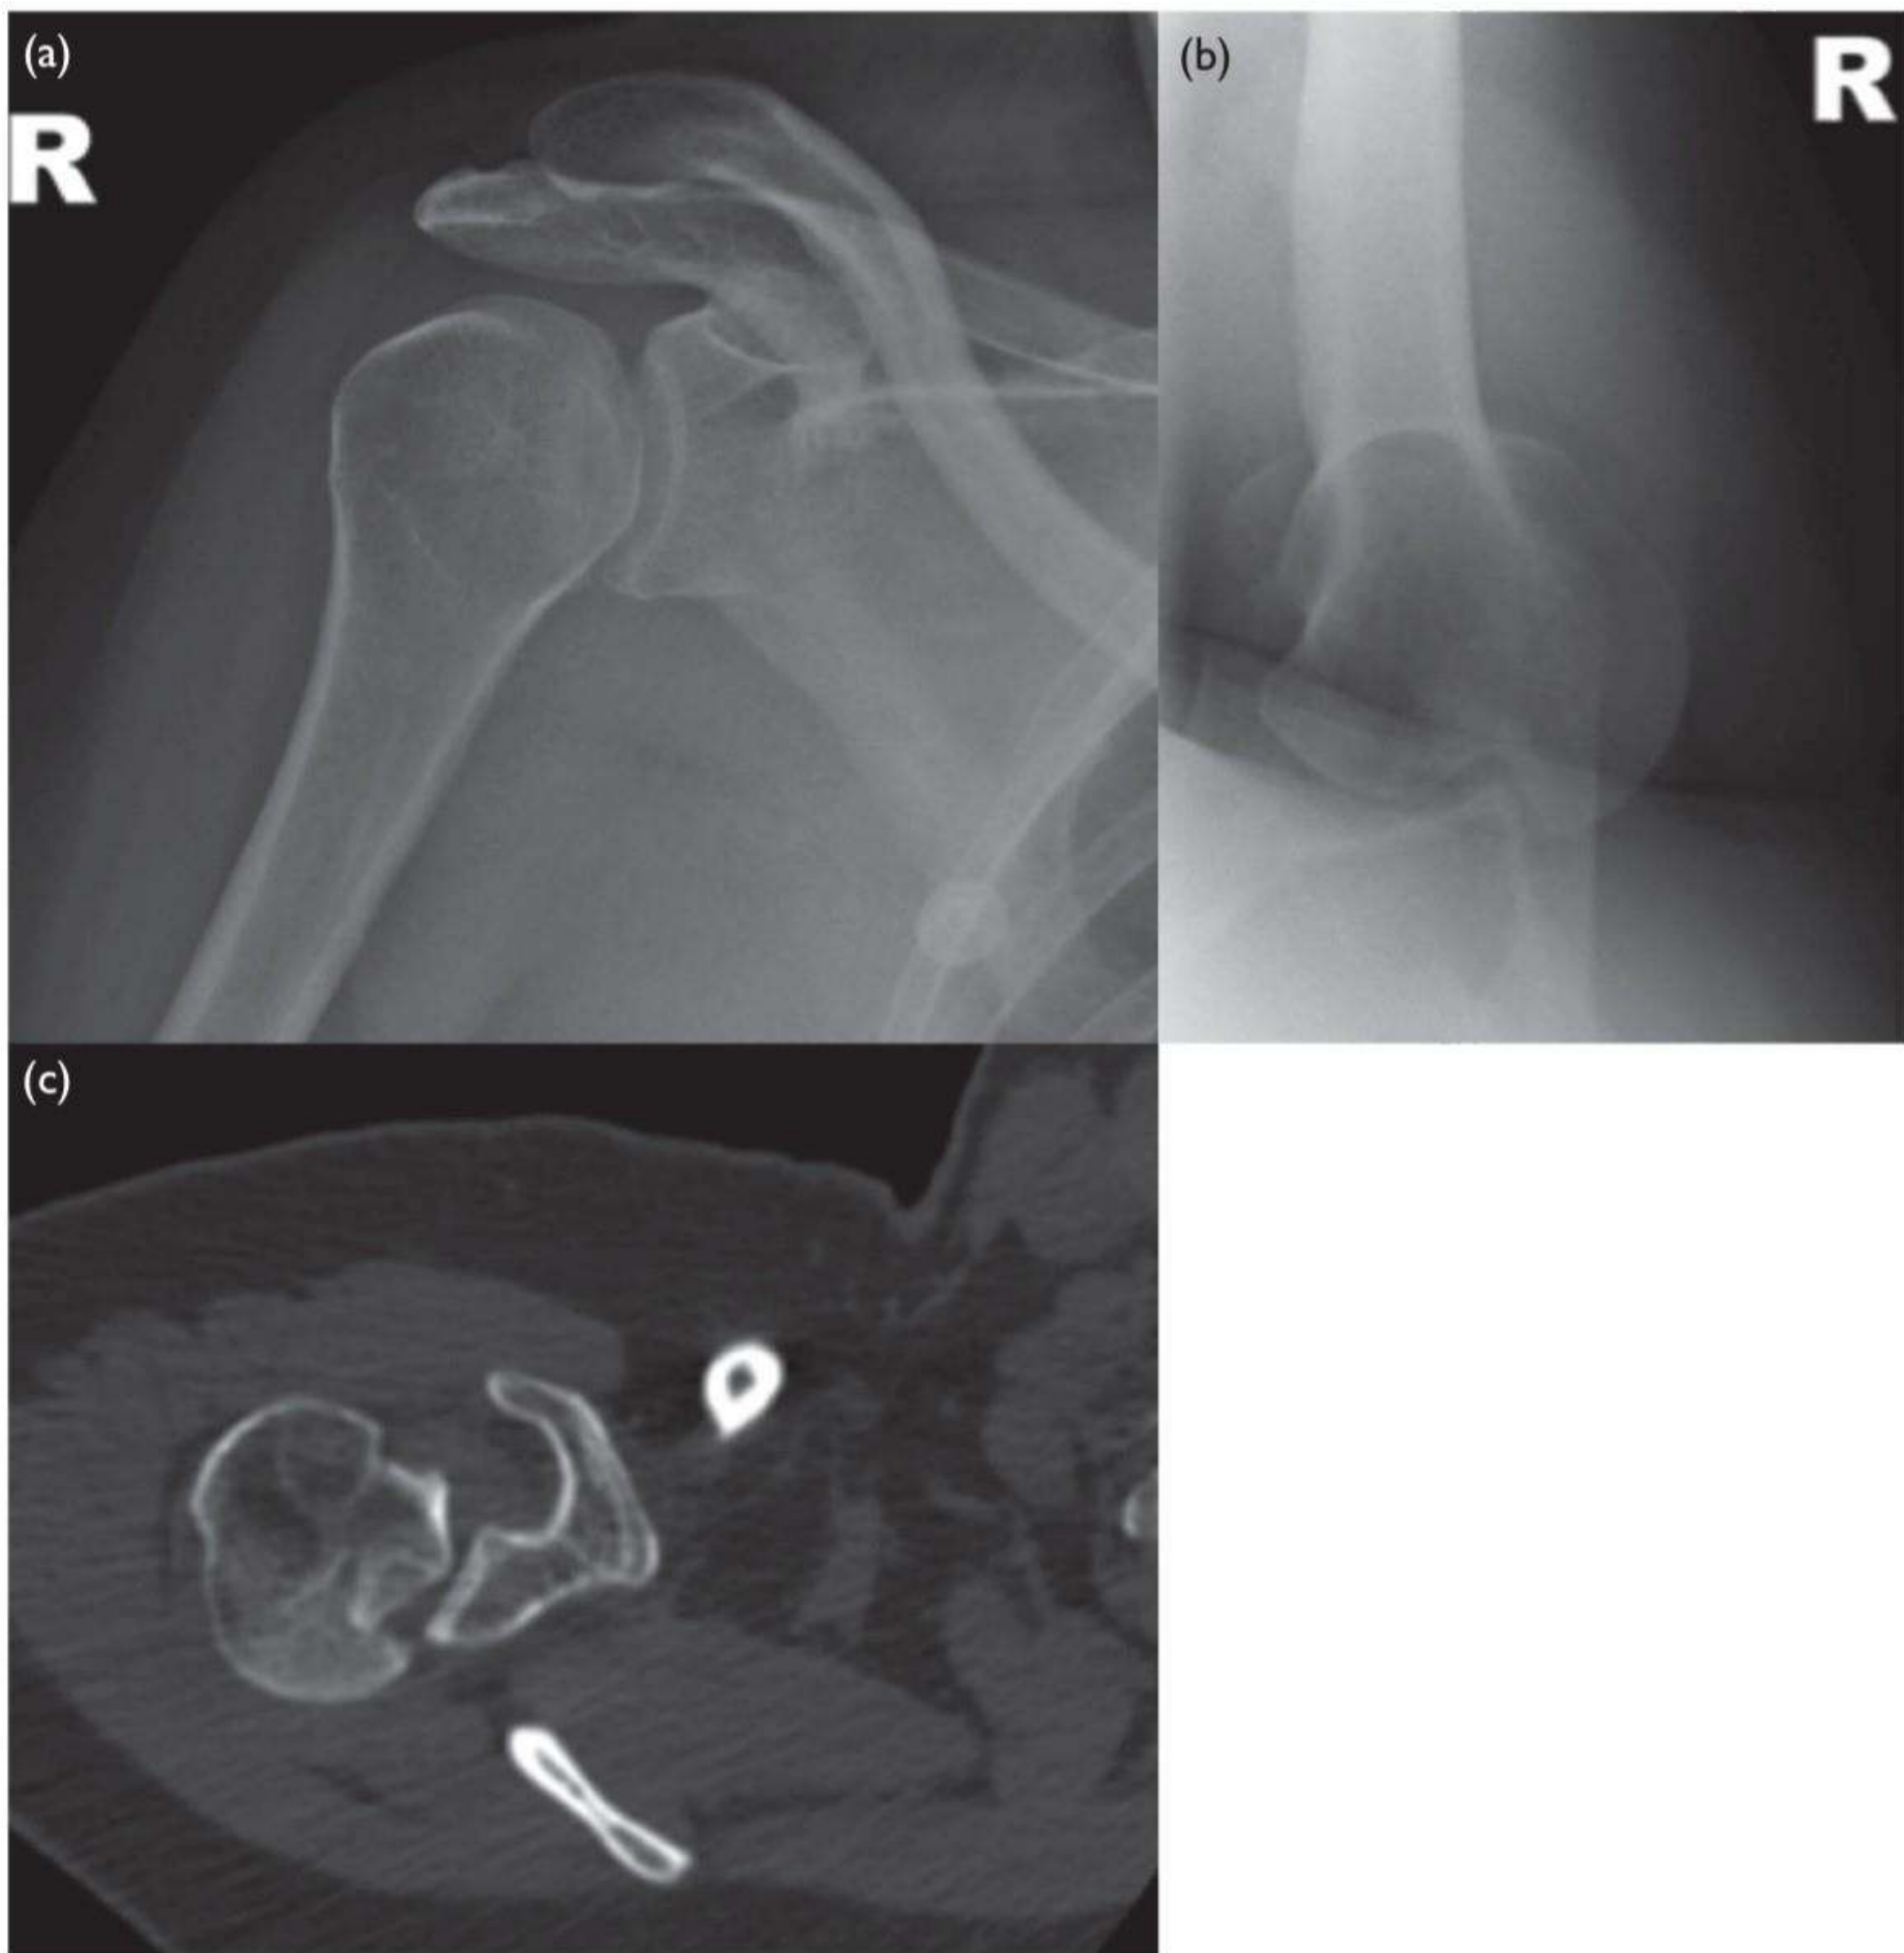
Right shoulder (a), (b) plain radiographs; (c) axial CT
